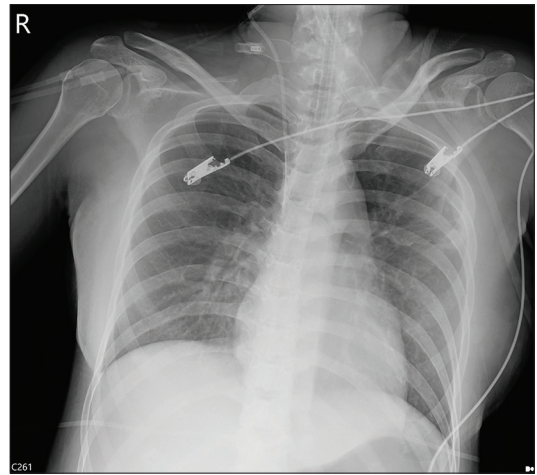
Follow-up chest radiograph after treatment showing resolution of pulmonary edema
